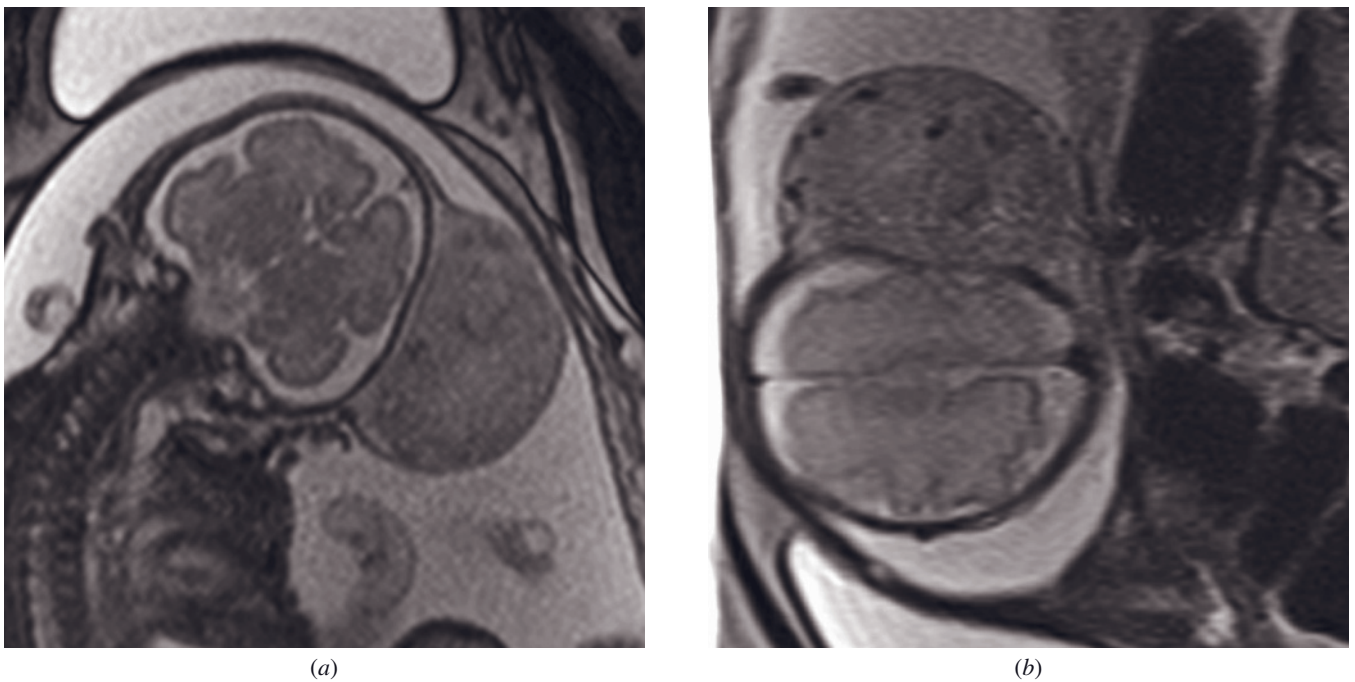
Congenital hemangioma. T2-weighted SS-ETSE images in coronal (a), axial (b), and sagittal (c) planes demonstrate a scalp hemangioma in a male fetus at 27 weeks of gestational age. There is a well-circumscribed extracranial mass originating from the soft tissues of the scalp. The underlying parietal bone and frontotemporal squama are intact. The mass is iso-/hyperintense with a hypointense pseudocapsule and prominent peripheral flow voids.
